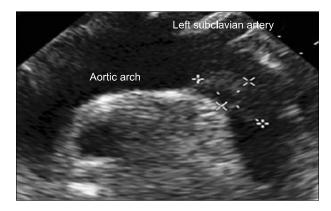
An echocardiography shows a floating lesion (3.0×1.5 cm) in the aortic arch.
